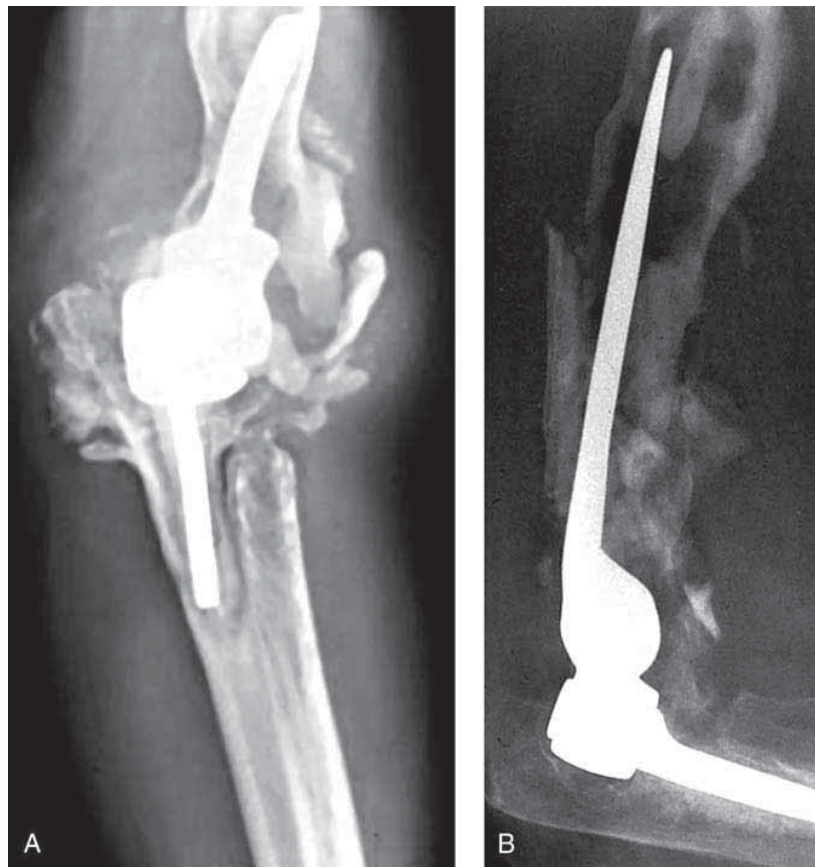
Metal-on-metal constrained articulation can generate many particles, resulting in extensive osteolysis, as seen in radiographs of total elbow arthroplasty using a Dee (A) or GSB II (B) prosthesis.
